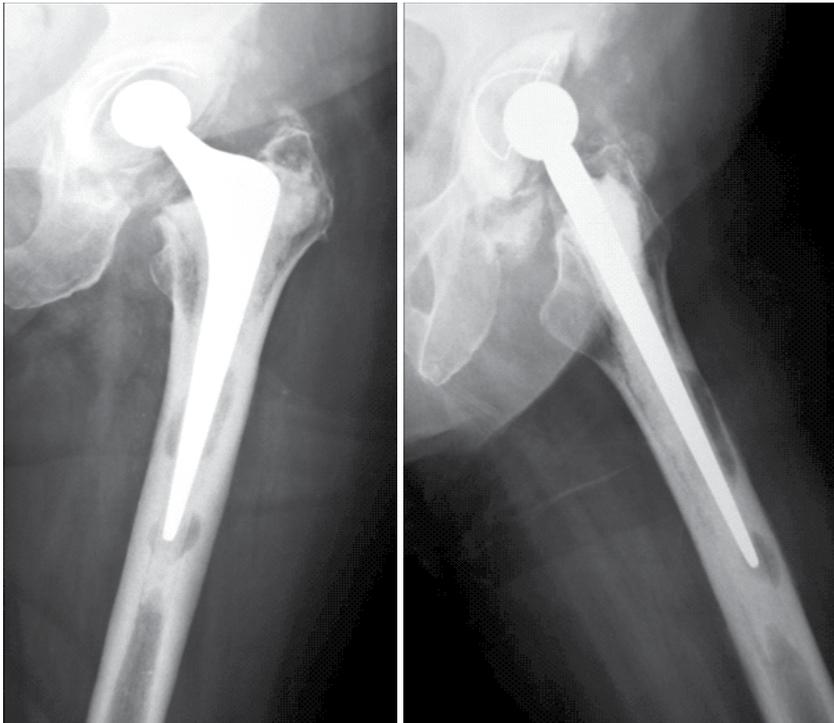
Plain AnteroPosterior and Lateral Radiographs showing focal areas of osteolysis, suspicious of PJI.
